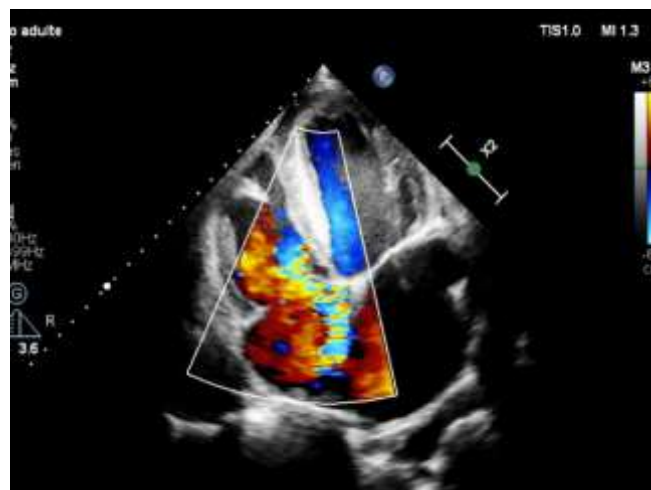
A: Transesophageal echocardiogram image showing a communication between the left and the right ventricle with a mobile vegetation attached close to the septal leaflet of the tricuspid valve with a severe tricuspid regurgitation. B: TOE in 4-chamber view showing a shunt between the LV and RA (Gerbode Defect) and a shunt between the LV and RV (case 1).
